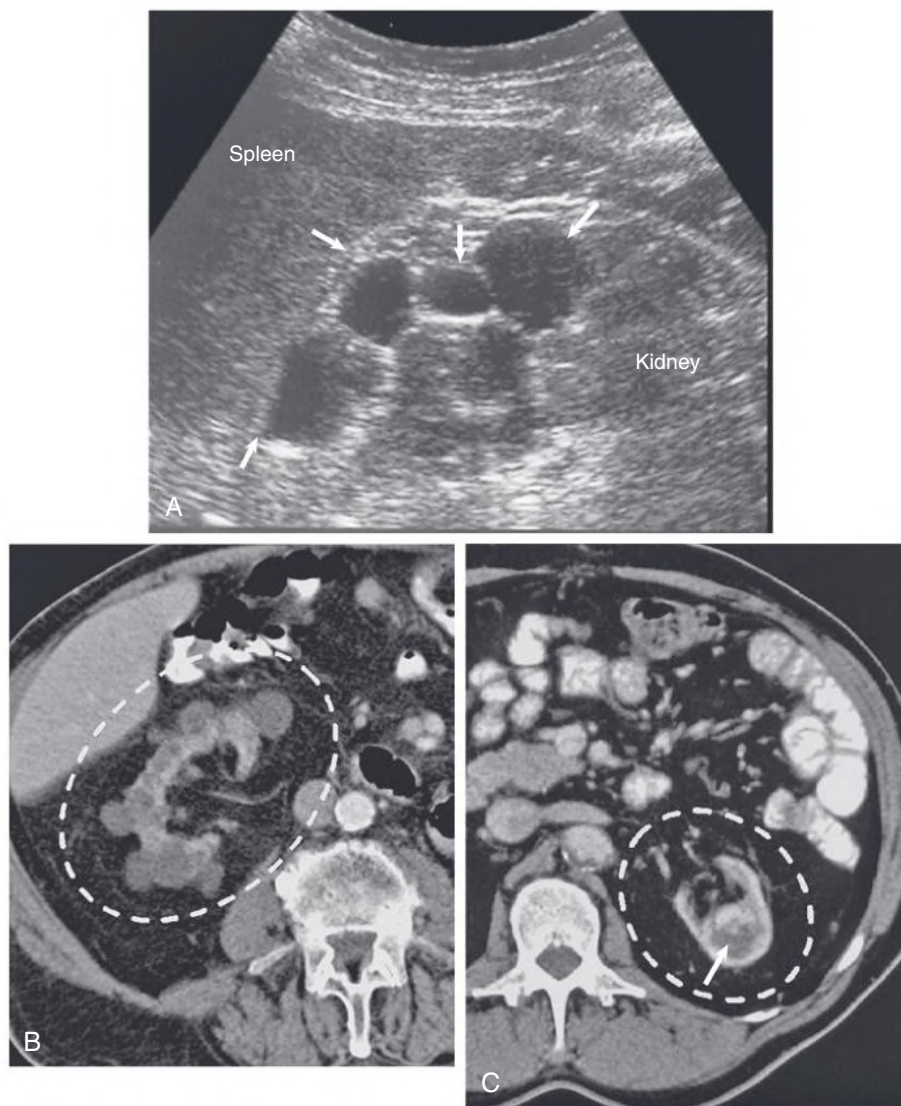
Imaging Studies in Acquired Cystic Kidney Disease (ACKD). (A) Ultrasound image of the left native kidney of a patient after 16 years of chronic hemodialysis (HD). Multiple cysts are present in the kidney cortex (*arrows*). (B) Computed tomography (CT) image of a patient after 5 years of chronic HD demonstrating multiple cysts within the right kidney (*dashed circle*). (C) Contrast-enhanced CT image of a kidney transplant patient who developed a renal cell carcinoma (*arrow*) originating from the left native kidney with ACKD (*dashed circle*).
